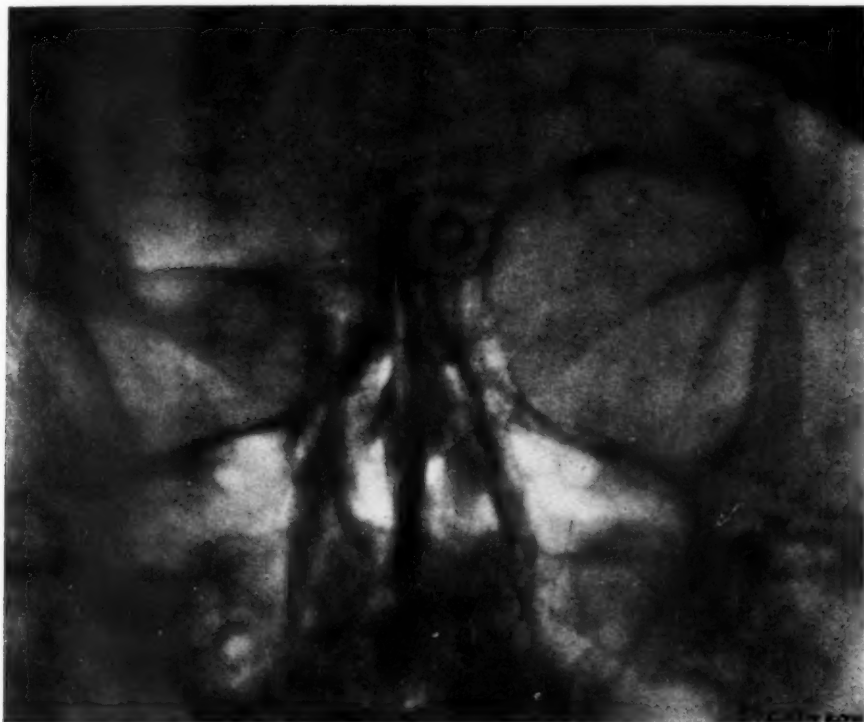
Radiographs of orbits and adjoining parts in adult after enucleation of left eye in early childhood. Overgrowth of bony walls of left orbit, especially above; with enlargement of left frontal sinus.
